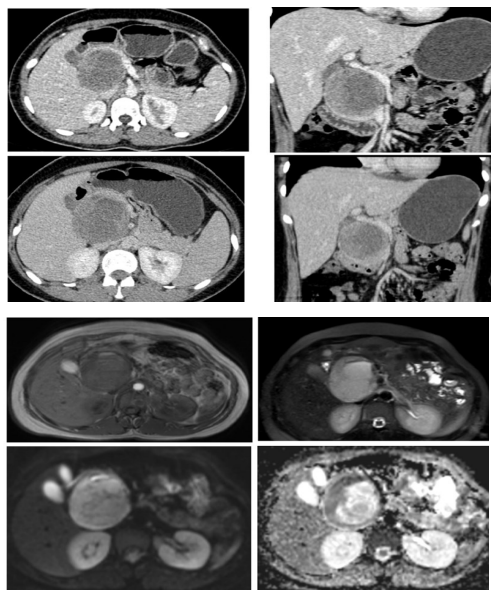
CECT shows heterogeneously enhancing solid-cystic lesion. MRI characteristics of the lesion – T1 hypo and T2 hyperintense heterogenous lesion showing restricted diffusion.
